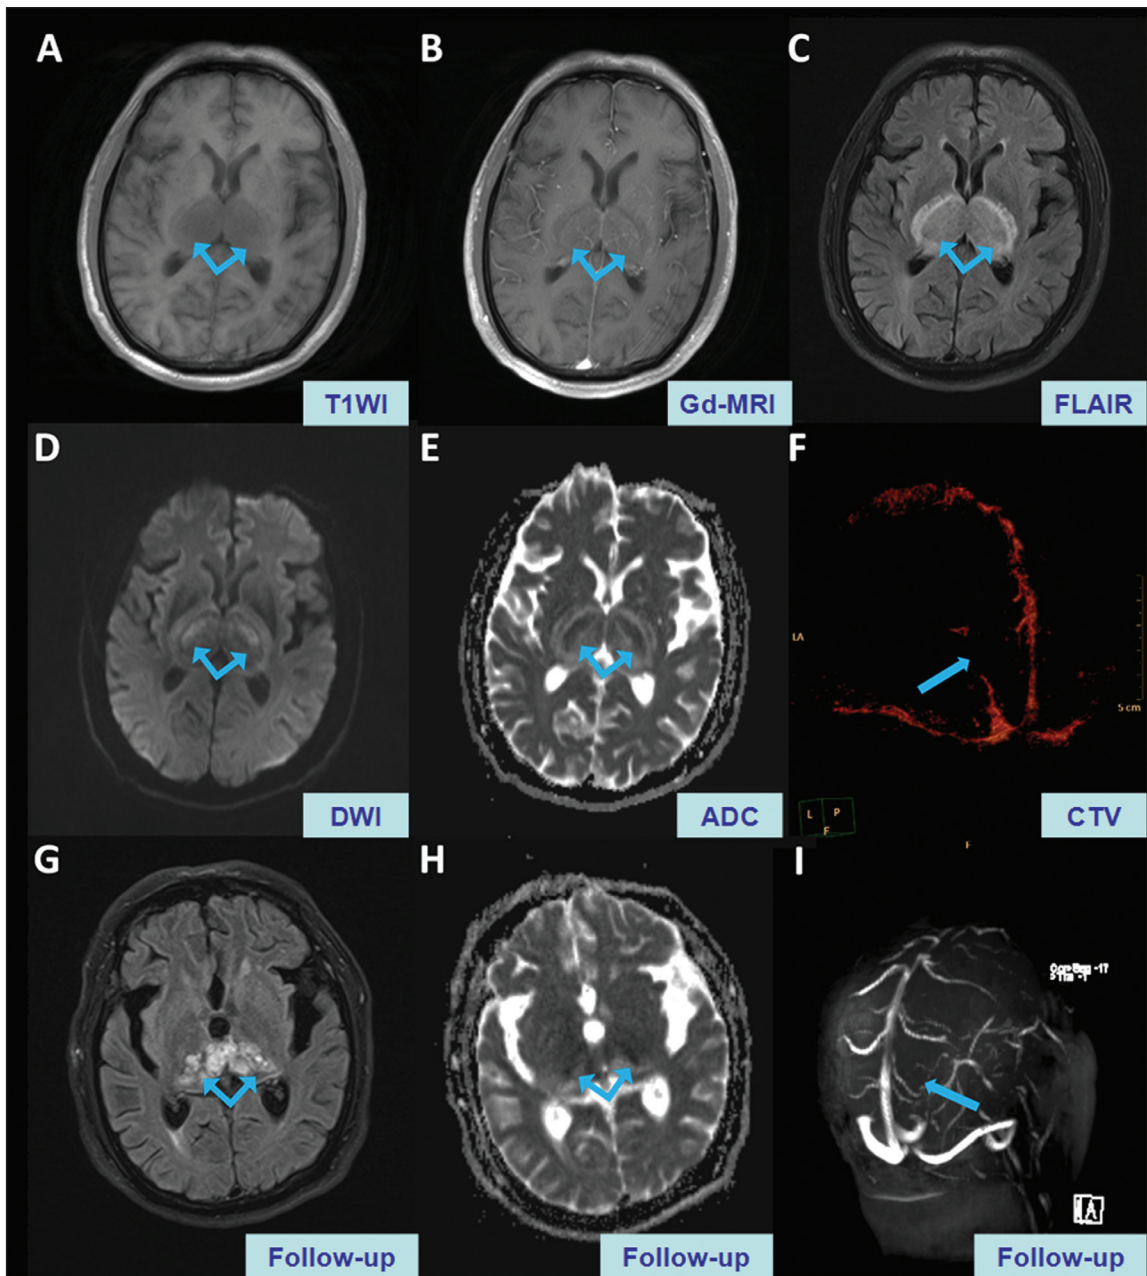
Magnetic resonance imaging showed abnormal signal intensity in the bilateral thalamus. The T1WI decreased (A); T2WI increased and FLAIR increased (C); DWI showed mixed intensity (D); and the ADC increased (E); Gd-MRI revealed mild enhancement (B). The straight sinus and the vein of Galen were inconsistently seen on CTV (F). Low-molecular-weight heparin was used and the patient gradually recovered. Magnetic resonance imaging re-examination performed 2 months later showed alleviated edema (G, FLAIR; and H, ADC), without the presence of the straight sinus on magnetic resonance venography (I).
